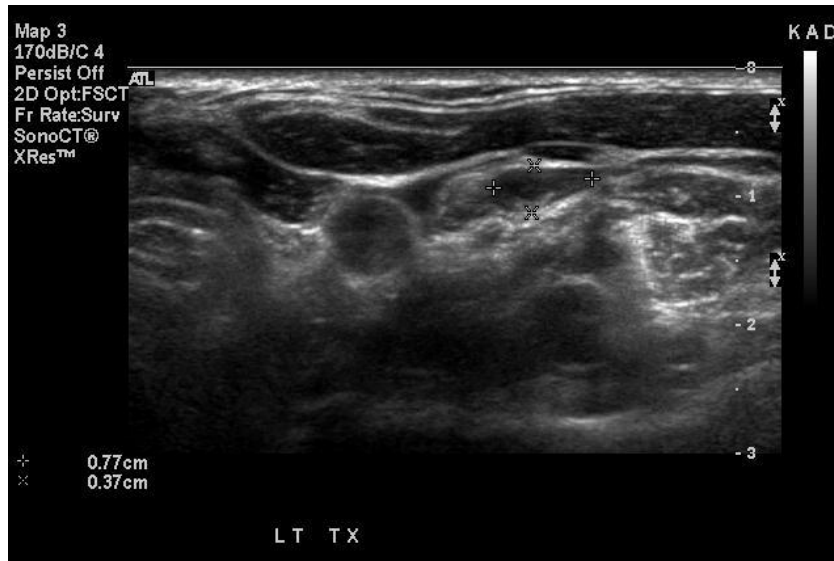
sonogram shows medullary carcinomas are typically solid, hypoechoic, and often have coarse central calcifications. ([www.wikipedia.com](http://www.wikipedia.com))
